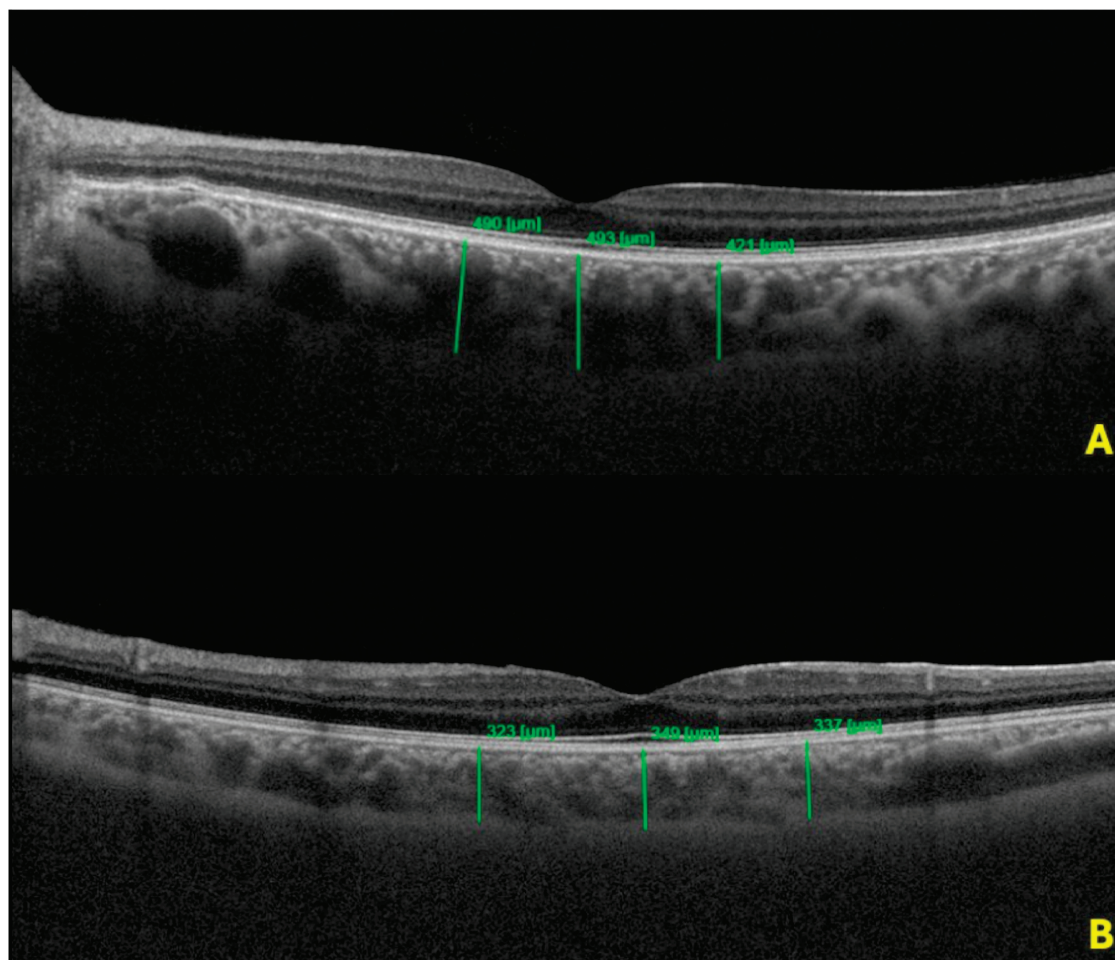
(A): Increased CT in the fovea, temporal to fovea, and nasal to fovea regions in a patient with VVS; (B): CT in the fovea, temporal to fovea, and nasal to fovea regions in a healthy control.
